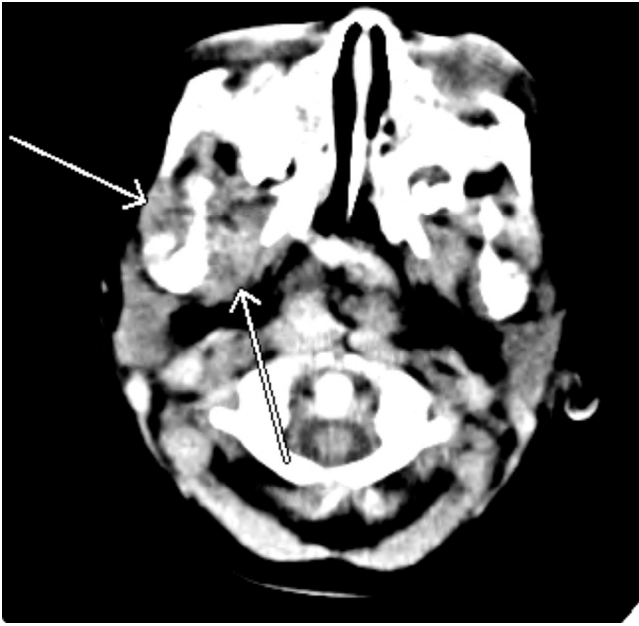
Axial computed tomography image shows a soft tissue mass with internal calcification centered on the ramus of the right mandible (arrows).
